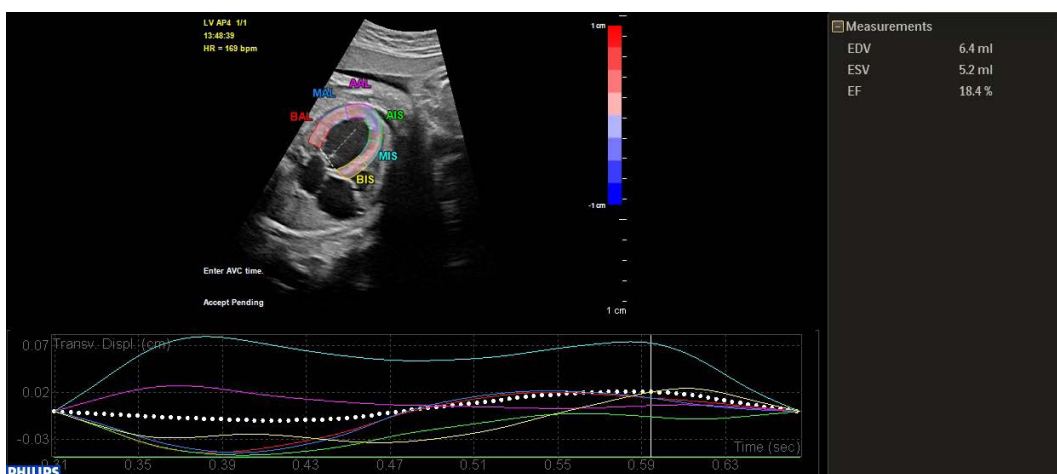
Apical four-chamber view. Left ventricle: traced myocardial wall and interventricular septum for myocardial deformation analysis (strain) using 2D speckle-tracking echocardiography. Curves for left ventricle transverse peak systolic strain (%) for six segments. BAL – basal lateral; MAL – middle lateral; AAL – apical lateral; AIS – apical septal; MIS – middle septal; BIS – basal septal
